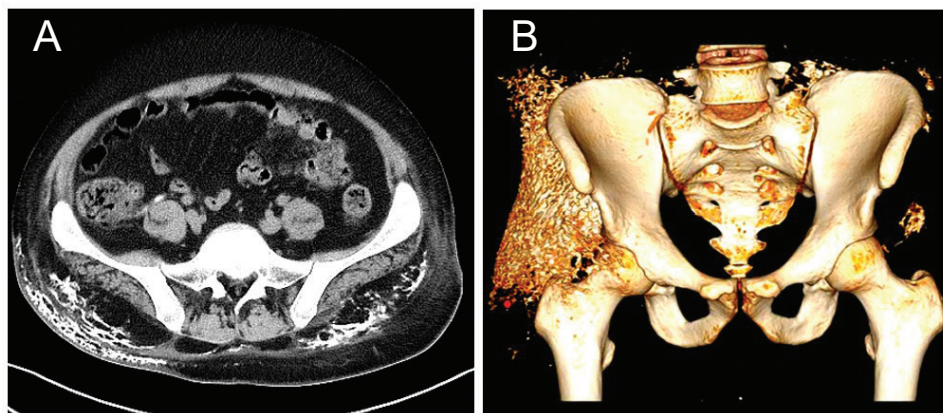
(A) CT cross-section reveals subcutaneous calcinosis of the pelvic wall (arrowheads); (B) CT stereo imaging of subcutaneous calcinosis (arrowheads).
